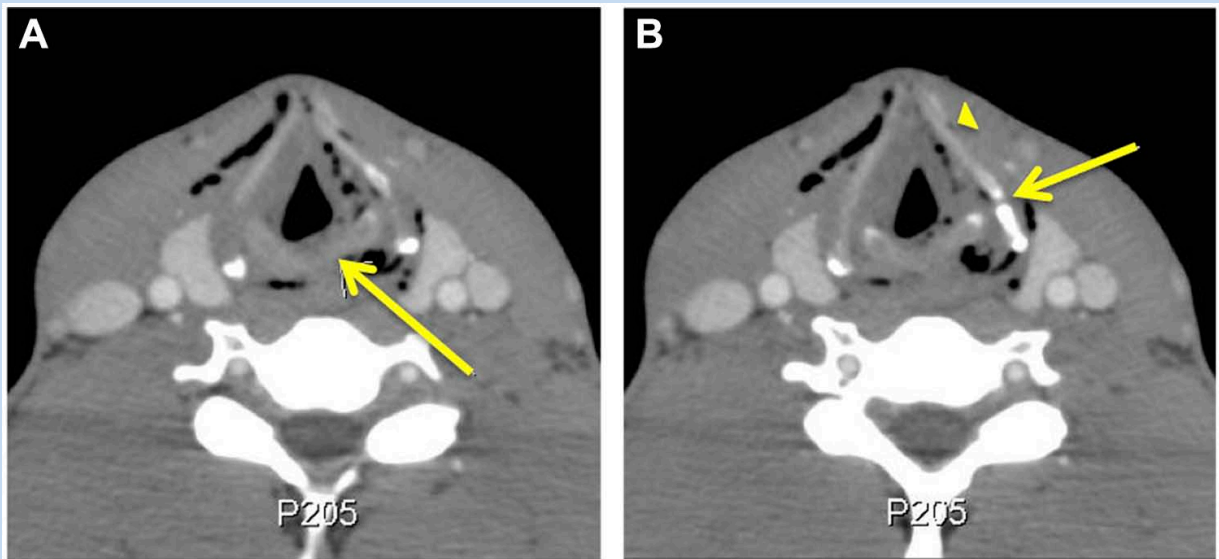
Two axial images from the patient's computed tomography scan of the neck. (a) The left posterior cricoid fracture (arrow) appears to be rotated laterally with the presence of submucosal and subcutaneous air present at the level of the larynx. (b) Double density along the anterior thyroid cartilage (arrowhead) and discontinuity more posteriorly (arrow) representing a thyroid cartilage fracture with the presence of subcutaneous air.
